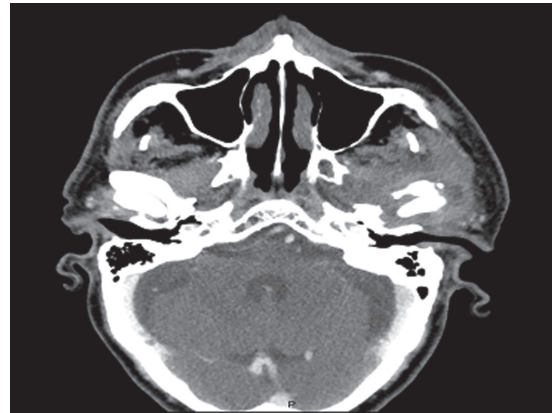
A CT scan with contrast from patient 2 demonstrates hypertrophy of the external ear canal, involvement of the infratemporal fossa, and a small collection of pus lateral to the temporomandibular joint.
